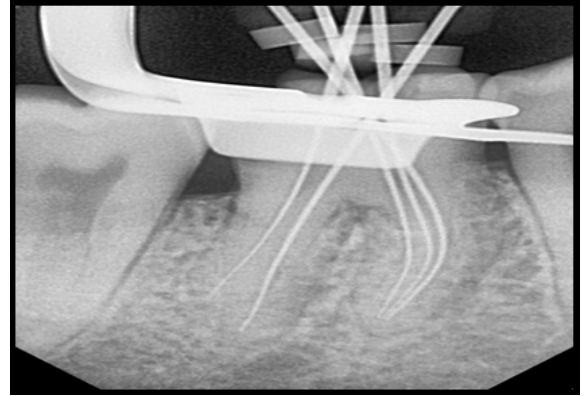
Working length determination radiograph of #46
